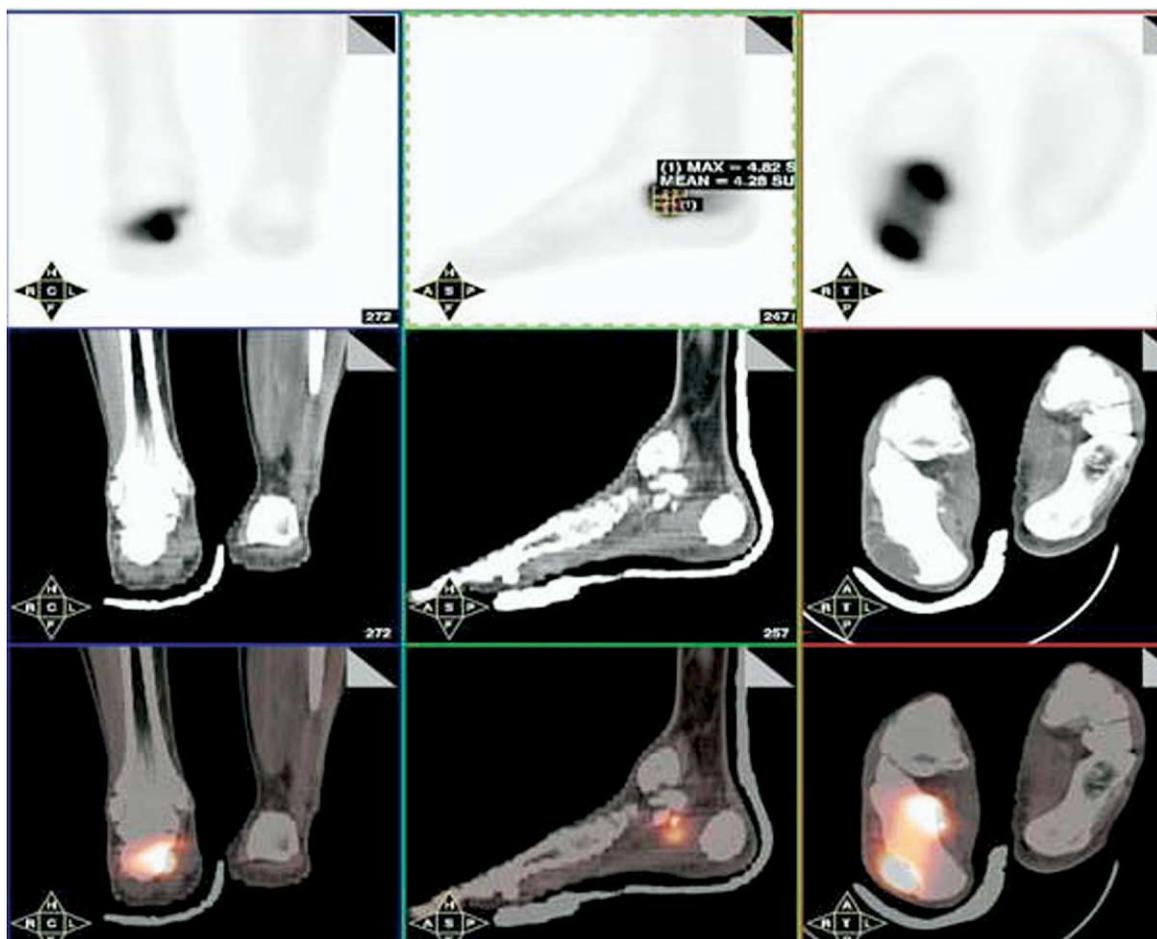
Shown is a 19-year-old male with left calcaneal osteosarcoma. PET-CT (upper panels: PET alone, middle panels: CT alone, lower panels: fused PET-CT) shows intense hypermetabolism (SUV = 3.5) in the tumor and the adjacent soft tissue. The patient was treated with below-the-knee amputation. (Coronal: left panel; sagittal, middle panel; axial: right panel.) (Color version of figure is available online.)
